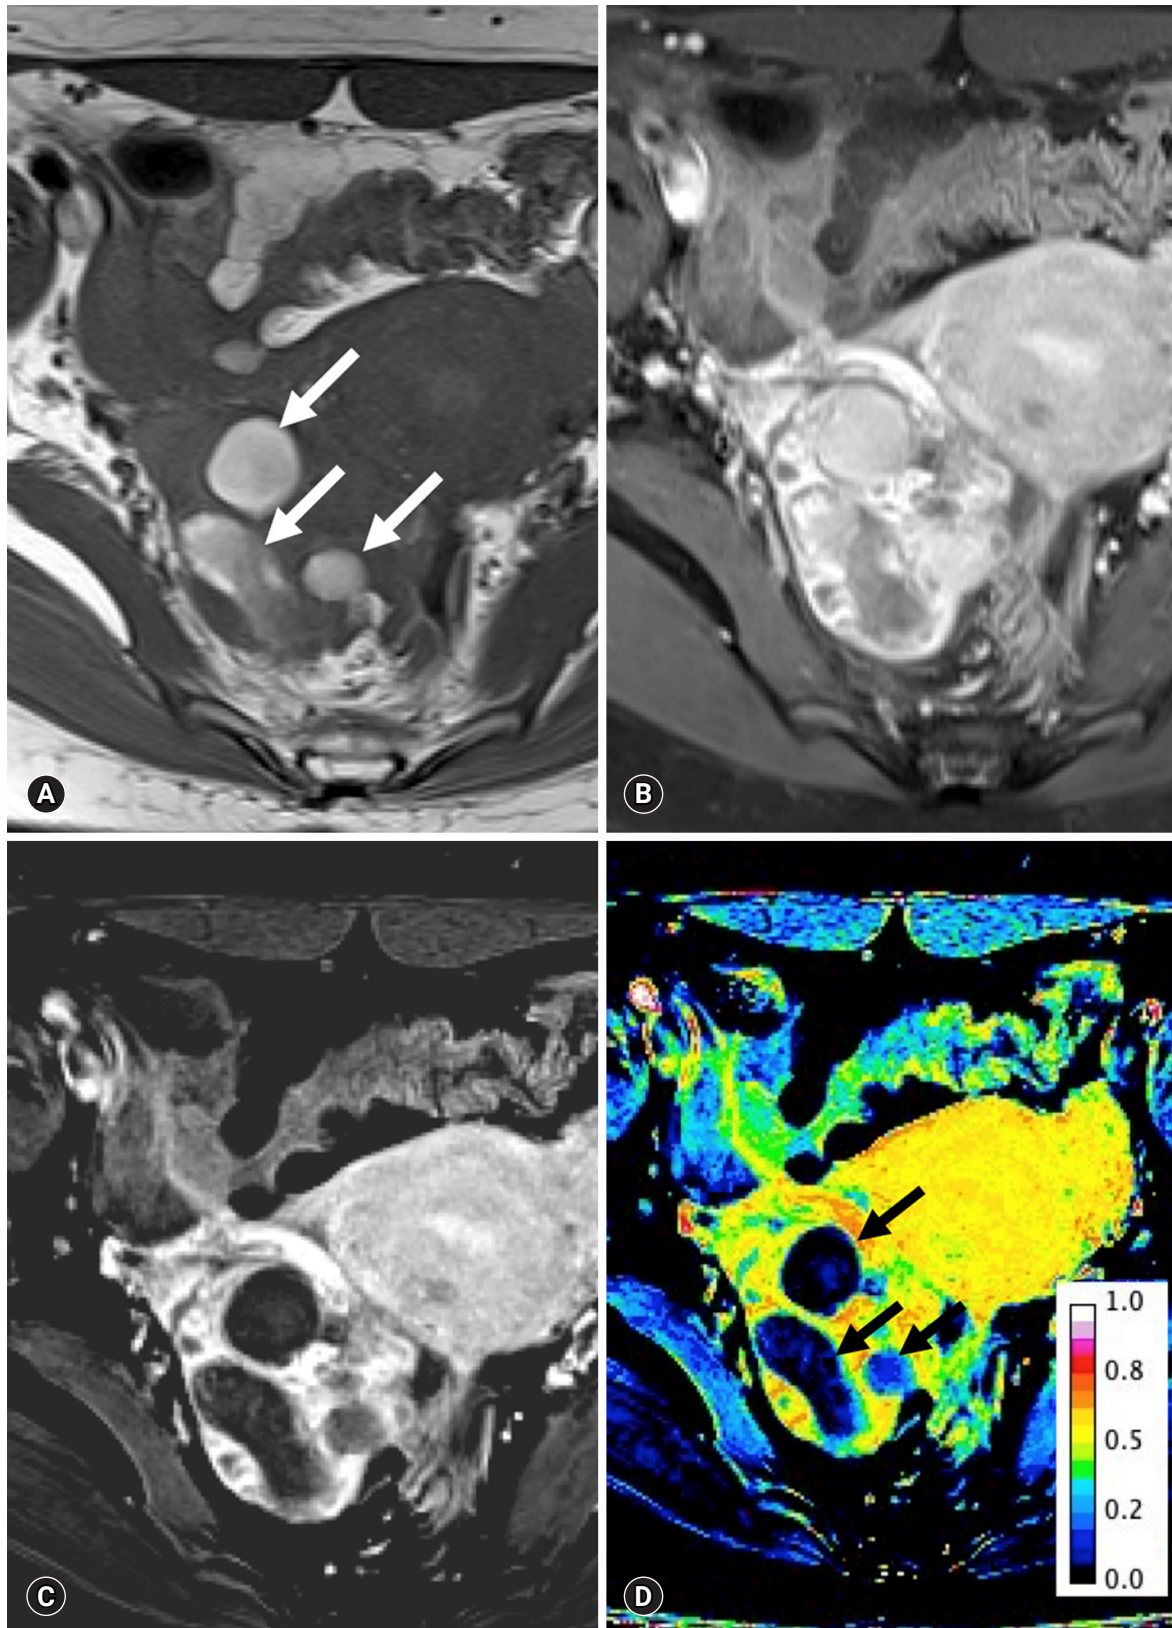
Multiple hemorrhagic cysts in a 36-year-old woman with endometriosis. The pre-contrast T1WI with fat suppression (A) and post-contrast T1WI in the arterial phase of enhancement with fat suppression (B) show multiple (arrows) high signal intensities. The subtraction image (C) shows low signal intensity, regardless of the pre-contrast imaging. The number of pixels ranges 0.01–0.12 (arrows) (D). T1WI, T1-weighted image.
